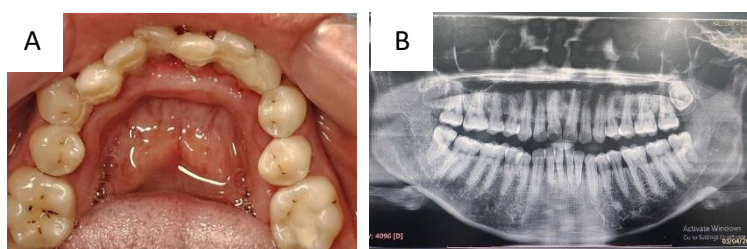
A. Intraoral condition after initial treatment, B. panoramic radiograph of initial condition.
